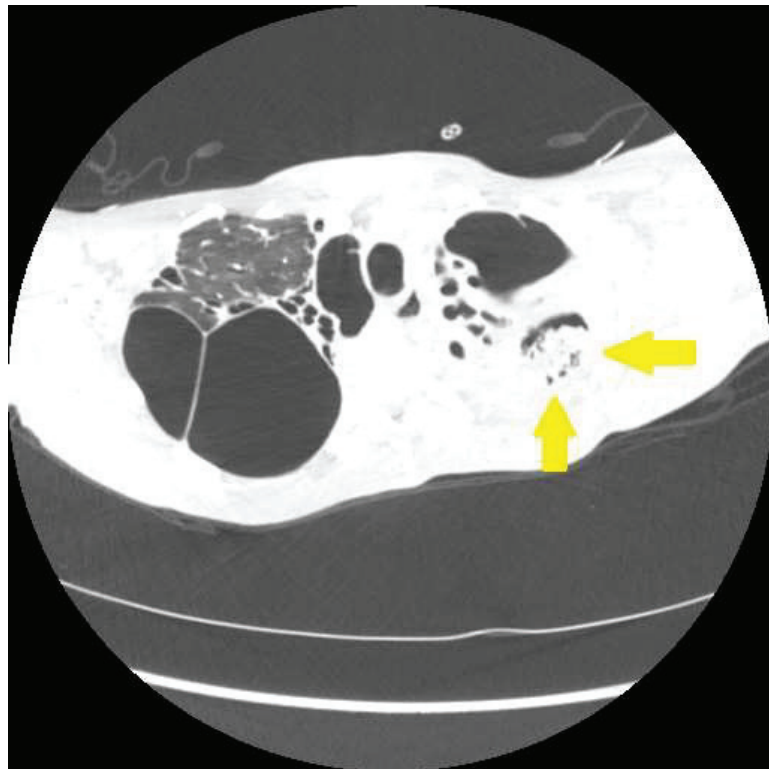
Chest CT scan of a fibrocystic pulmonary sarcoidosis patient demonstrating a mycetoma (arrows). These are often associated with significant pleural thickening.
